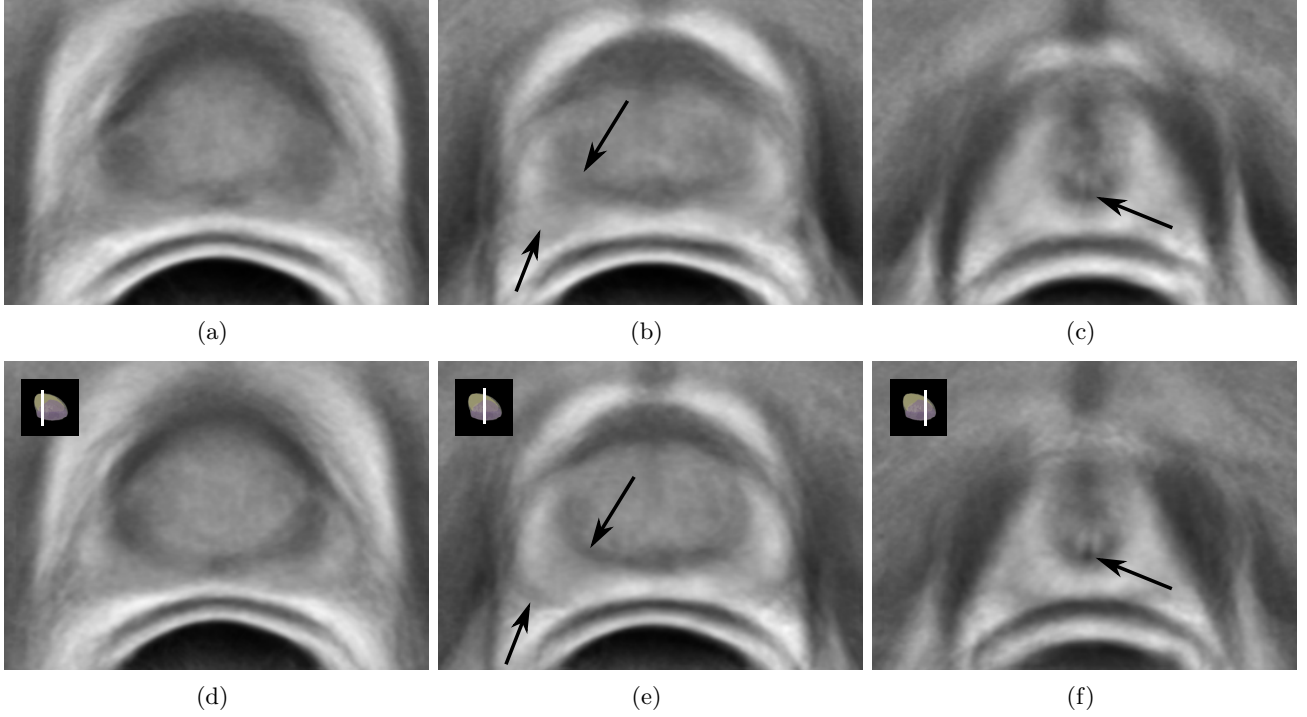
Intensity statistical atlas as obtained in (a)-(c) \mathcal{A}_I , T2-w MRI intensity based registration *without* Pr and CG constraints; (d)-(f) \mathcal{A}_A , AnCoR framework with equal contributions from CG and Pr; (a), (d) base; (b), (e) midgland region; (c), (f) apex. The CG and Pr boundaries are more readily identifiable in \mathcal{A}_A compared to \mathcal{A}_I (see arrows in (b) and (e)). Moreover, the urethra is more clearly discernible in \mathcal{A}_A relative to \mathcal{A}_I (see arrow in (c) and (f)).
